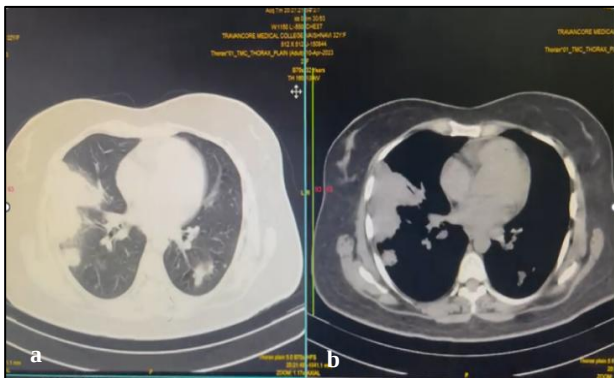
(a and b): CT image of right middle and lower lobe consolidation.
